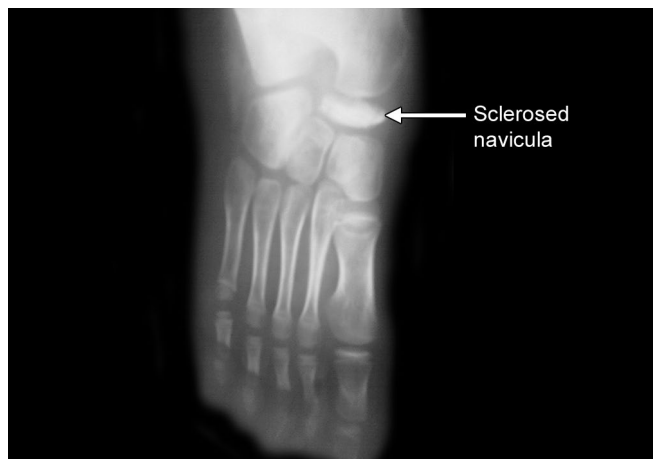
X-ray of foot showing sclerosed navicula in a patient with Kohler's disease.
